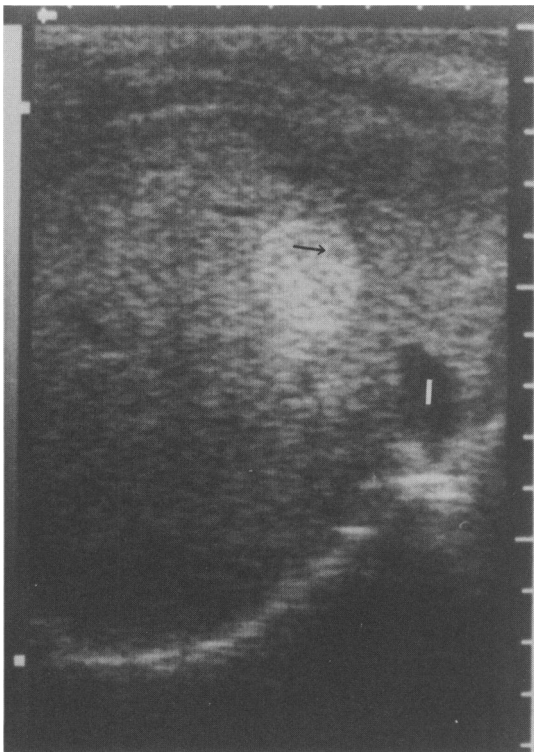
Transverse sonography of the liver showing a well defined 2 cm echogenic lesion antero-lateral to the inferior vena cava (I) in the right lobe. A very small hypoechoic 'nodule' (arrow) is present within the lesion.
